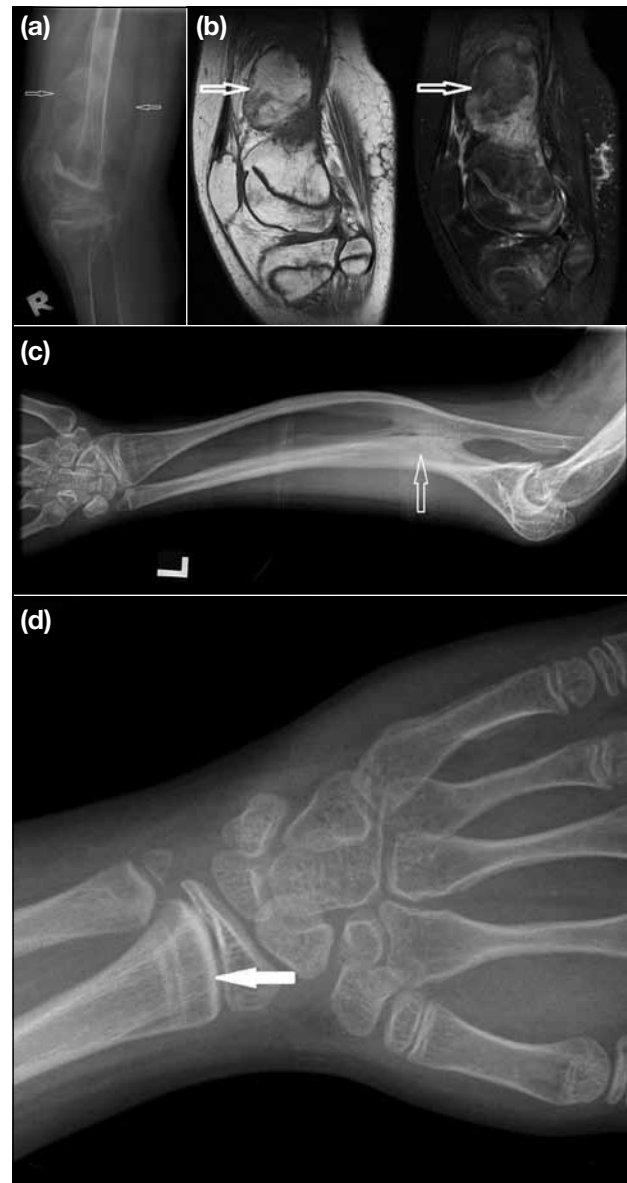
Patient 1: (a) A lateral radiograph of the right knee: he developed painful swelling at the right distal femur 3 months after anterior wedge osteotomy; this radiograph shows multi-lobulated, calcified masses at the right distal femur around the operative site (open arrows). (b) Corresponding magnetic resonance images of the right knee after operation: selected sagittal (left) T1-weighted (T1W) and (right) T2-weighted (T2W) images of the right distal femur demonstrated lobulated, well-defined T1W hyperintense, T2W hypointense lesions around the operative site, with the appearance of tumour mass (open arrows). Biopsy of the lesion was performed, which showed no evidence of malignancy. It was considered to represent hypertrophic callus formation. (c) A radiograph of the left forearm: there were generalised osteopenia, bowing of long bones, and grade III radioulnar interosseous membrane ossification (open arrow). (d) An anteroposterior radiograph of left distal radius showing radiodense metaphyseal band adjacent to the growth plate (solid arrow), another characteristic feature of osteogenesis imperfecta type V.
